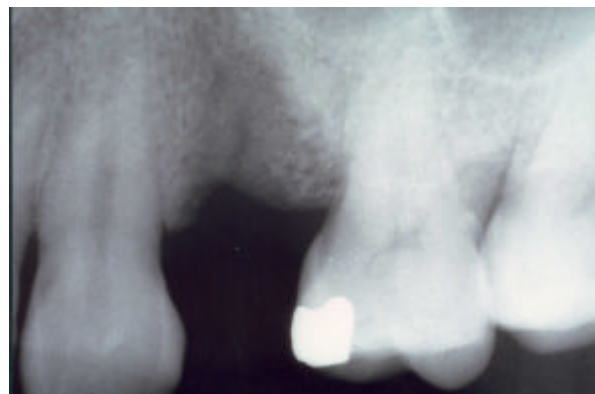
Intra-oral X-ray of the site after 4 and a half months. The radiograph shows neotrabeolum bone which appears to be greater at the apical portion.
